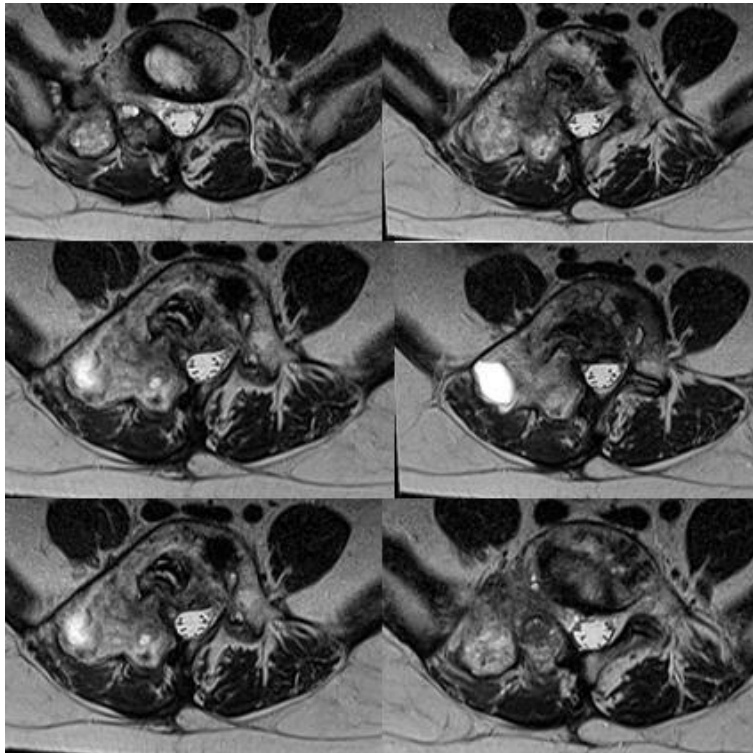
MRI 3 months after completion of IMRT - The tracked heterogeneous mass is presented with significant regression and reduction of most of the cystic bone components with no sediments between them in the form of levels. The bone structure is heterogeneous, with confluent T2 and STIR hyperintense areas, without cortical erosion. Residual cyst lateral to the protruding bone structure of L5 measuring 1.5/1.9 cm.
